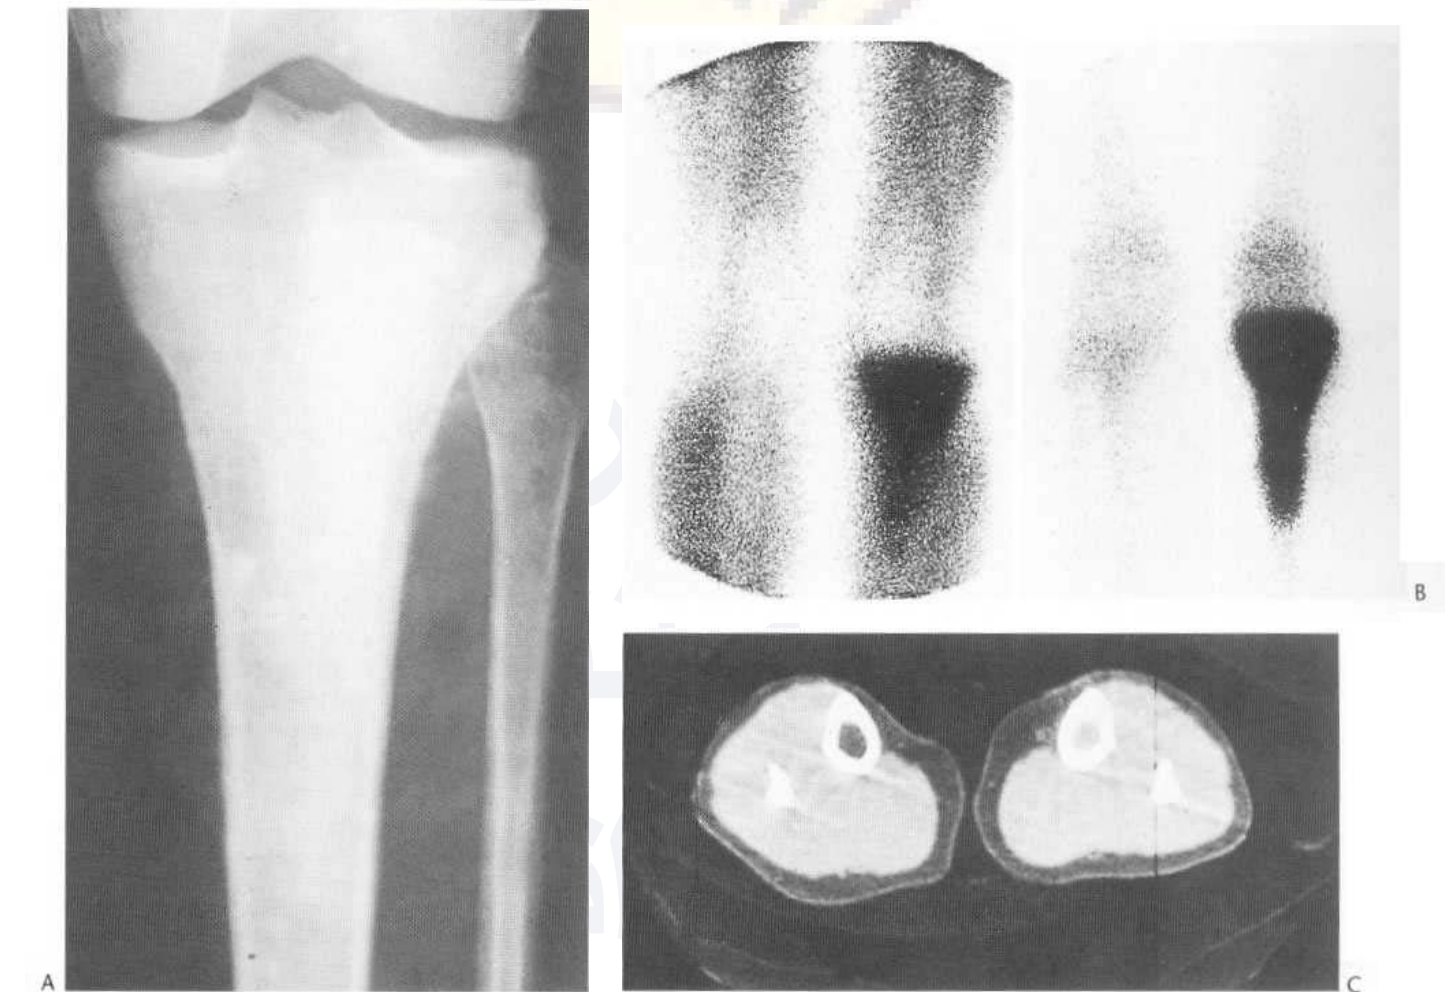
Osteoblastic osteosarcoma of the proximal tibia. (A) The conventional radiograph reveals patchy increased density in much of the upper tibia. Note a little new bone laterally. (B) A scan in the early blood-pool (left) and delayed phases (right) demonstrates an extensive abnormality. Note the activity is more uniform and extensive than the apparent involvement shown on the plain film. The distal extent of the tumour is confirmed however by (C), a CT scan which shows a subtle change in marrow attenuation below the level of the apparent tumour on plain film, an example of how CT may be used to gauge the extent of marrow involvement.
